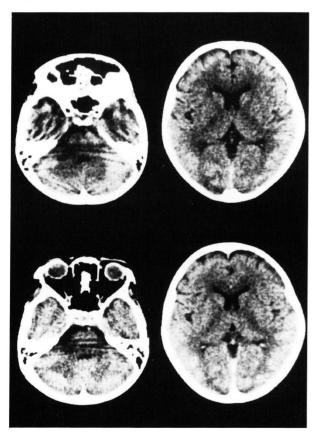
A CT on the day of admission demonstrated decreased density areas in bilateral occipital areas and left cerebellum. No contrast enhancement was observed (lower panel).
